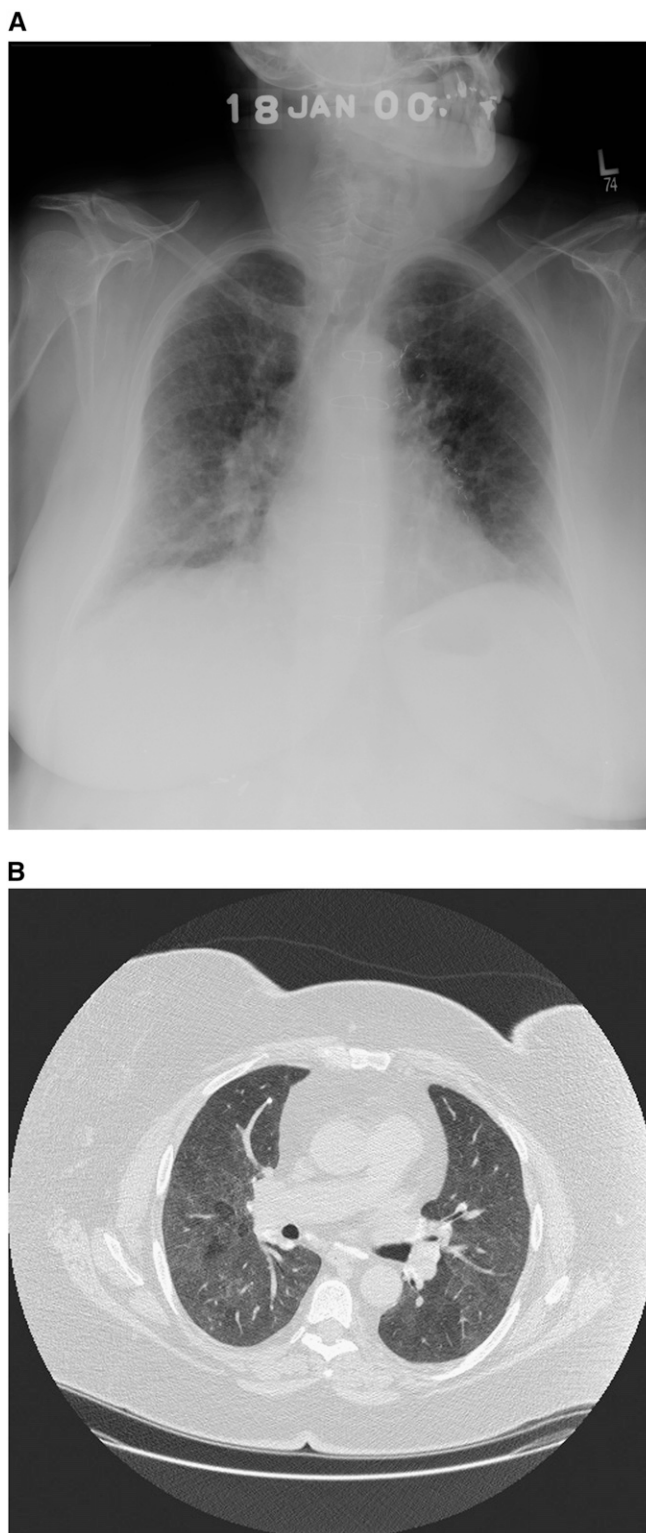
Chest imaging from two of the cases of community-acquired chronic beryllium disease (CBD). (A) A representative posteroanterior chest radiograph from case 1 demonstrating upper lobe predominant reticulonodular opacities, consistent with CBD. This patient had a prior median sternotomy for atherosclerotic heart disease, which is evident on the radiograph. (B) A representative high-resolution computed tomography scan lung window from case 1 demonstrating ground-glass opacifications and calcified hilar and mediastinal adenopathy.
